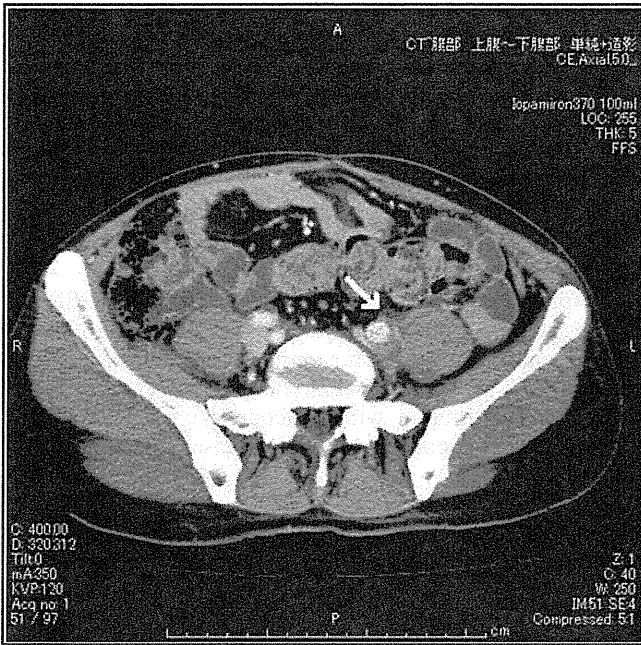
Computed tomography of Case 2 on admission.
